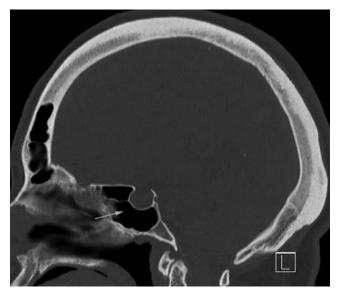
Sagittal bone window CT scan showing voluminous sphenoidal sinus (arrow) in a patient with acromegaly. The increased anteroposterior diameter lengthens the transnasal working distance to the floor of the sella turcica. Note the increased thickness of the cranial vault and the prominent frontal sinus.
